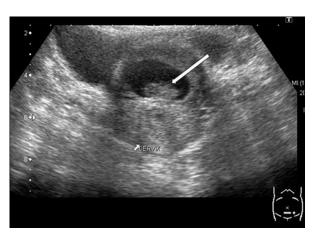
Transabdominal sonography showing gestational sac in anterior myometrium of lower uterine segment, which shows a fetal pole (thick white arrow) within.
